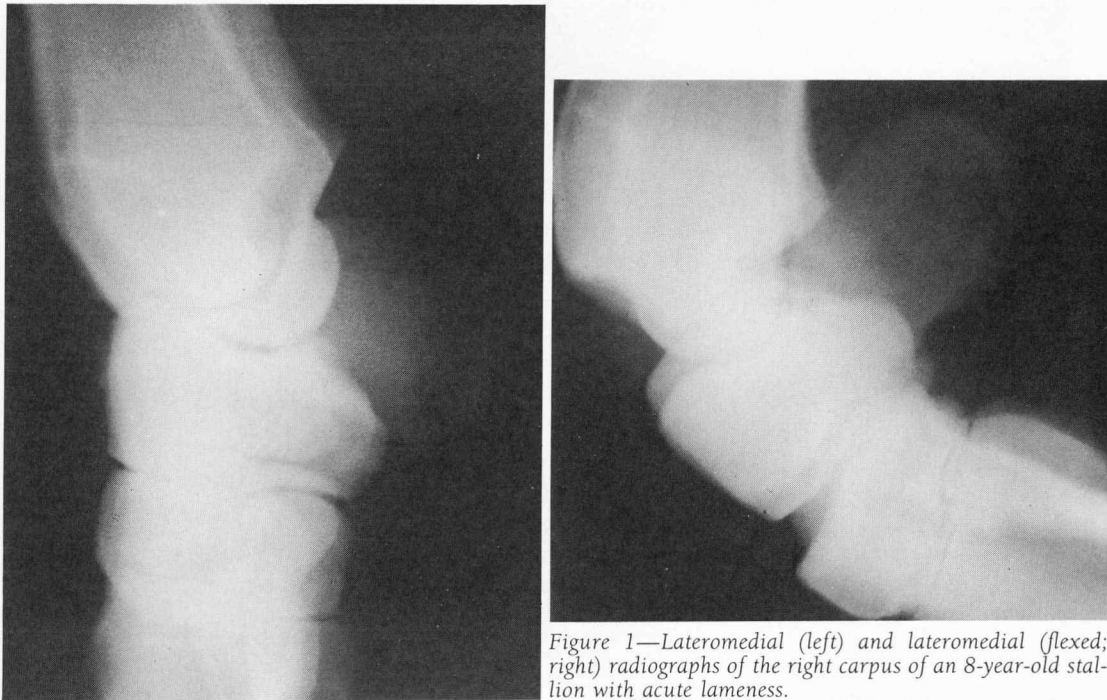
Lateromedial (left) and lateromedial (flexed; right) radiographs of the right carpus of an 8-year-old stallion with acute lameness.
